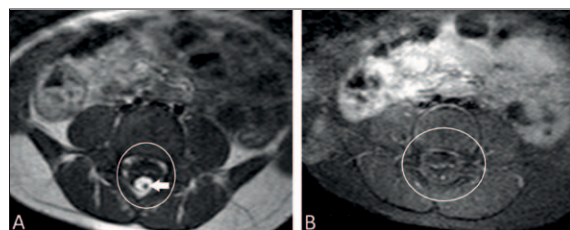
Axial section MRI in T1 sequence without contrast in A and T1 FAT SAT sequence with contrast in B demonstrating a lipoma between the dura and the bony wall in the extradural space (white circle) without contrast enhancement and the intracanal lipoma (white arrow).
